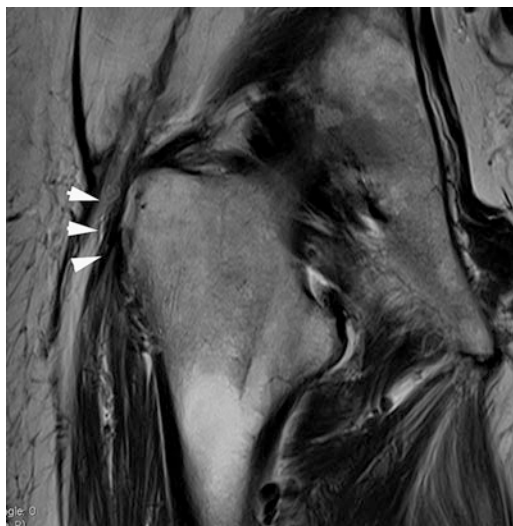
T2-weighted coronal image of an 82-year-old female patient (TR 4,000 ms, TE 70 ms, slice thickness 6 mm) shows a full thickness tear of the gluteus medius tendon. No tendon attachment (*white arrowheads*) onto the lateral facet of the greater trochanter is shown
